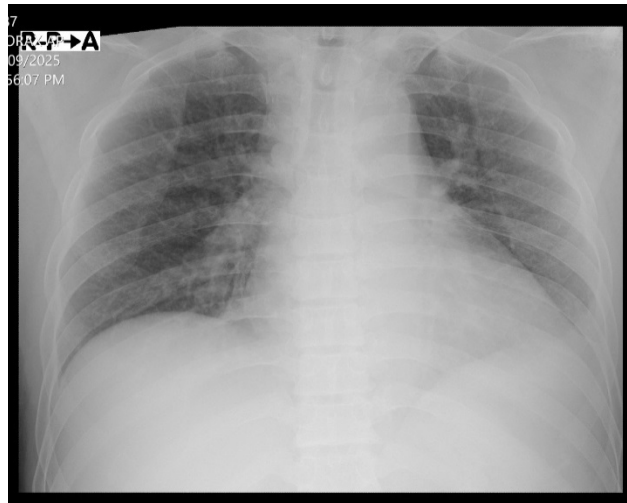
Chest X-Ray of MR. S
